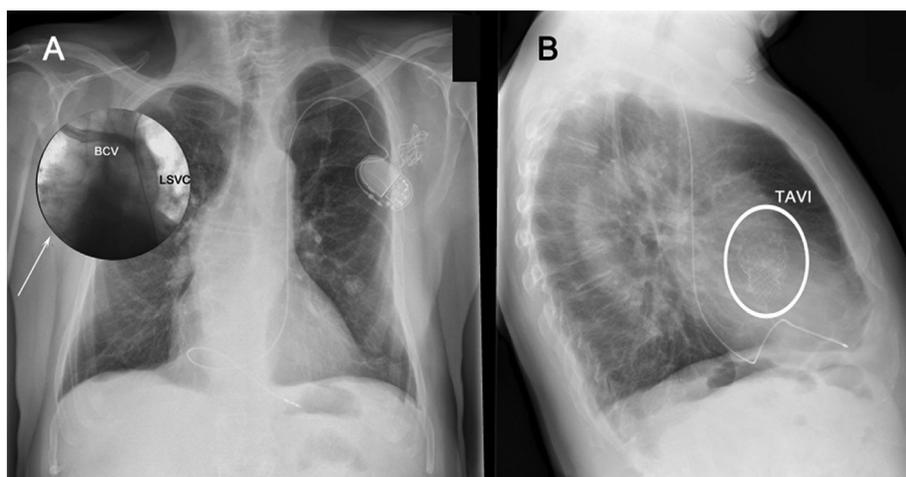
(A, B). Case 6. Radiographic image of lead position in PLSV (arrow →, venography reveals a lack of RSV) and the position of the implanted 29-mm aortic Medtronic Core Valve in (A) posterior-anterior and (B) lateral views.
